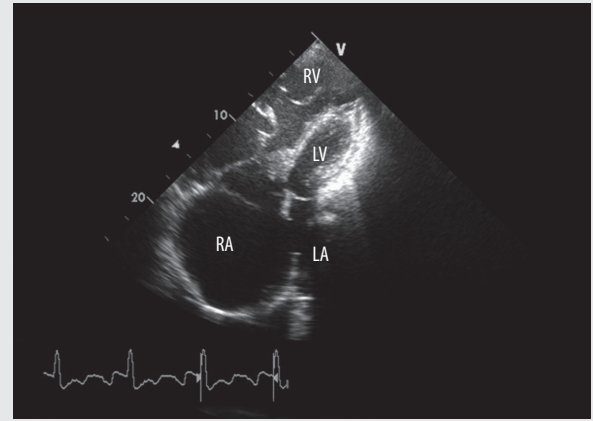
Echocardiography. Four chamber view. RA and RV enlargement (areas of 89.09 and 74.6 cm², respectively). Compression of the LV (area = 17 cm²). RA – right atrium, RV – right ventricle, LA – left atrium, LV – left ventricle
